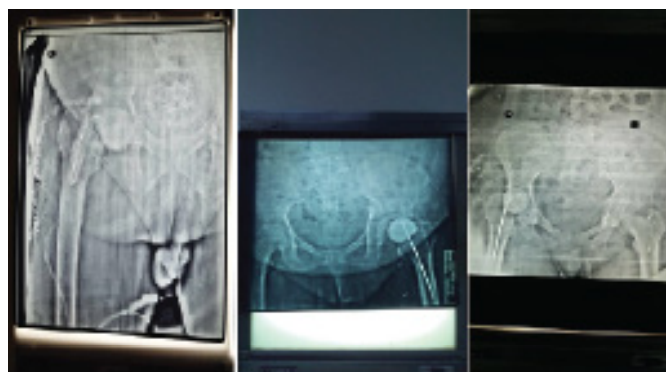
Antero-posterior pelvic radiograph post-operative x-ray show handmade spacer.
